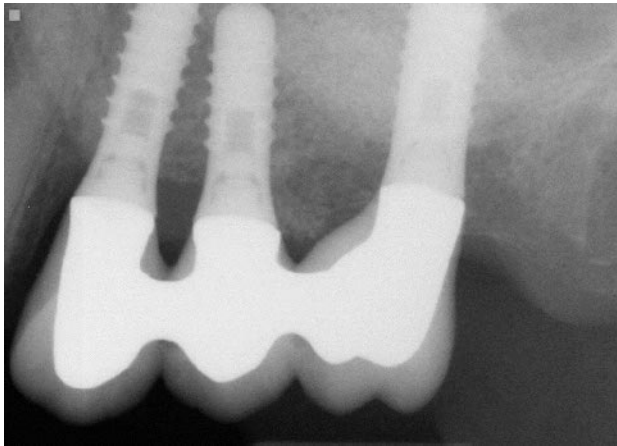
Eight months following sinus augmentation therapy, radiographic evidence of extensive bone regeneration in the created subantral space is noted.
